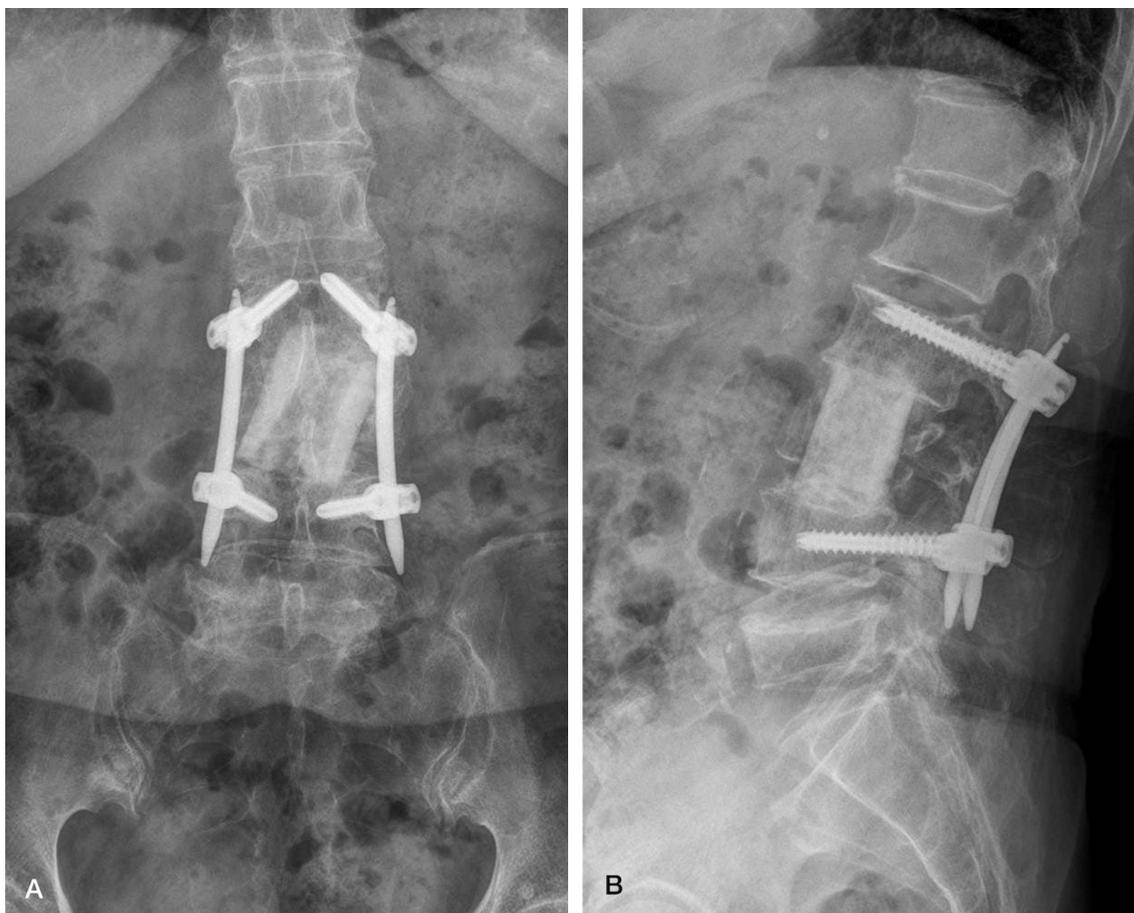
(A) AP and (B) lateral radiographs which were taken after 2 years of follow-up show a solid bony fusion.
